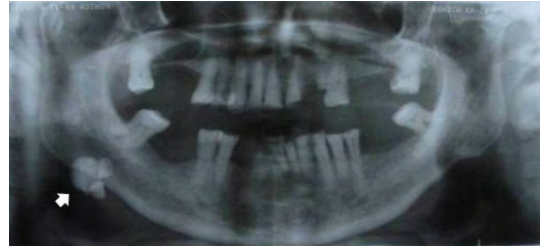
Panoramic radiograph demonstrating a large radiopacity measuring approximately 2x2 cm overlapping the antegonial notch of the right angle of the mandible. (White arrow)
